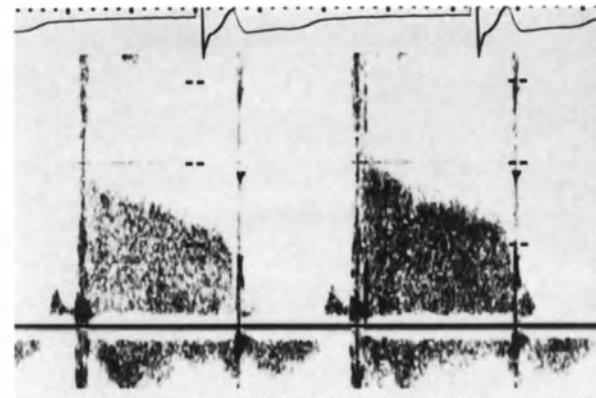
Continuous wave Doppler of a patient with severe mitral stenosis. Pressure time is approximately 300 ms and indicates a valve area of approximately  $0.7 \text{ cm}^2$ .
